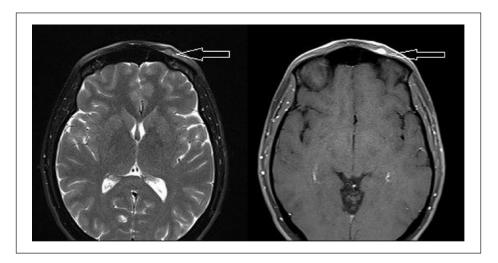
Preoperative MRI revealed solid mass keeping intensive contrast in the nasal part of superior orbital rim (arrows): (a) axial MRI without contrast and (b) axial MRI with contrast.
